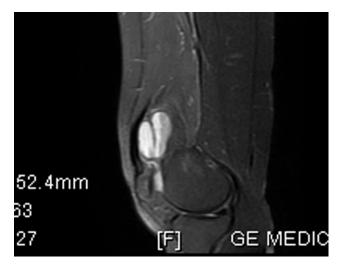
Sagittal magnetic resonance imaging sequence of right thigh shows ganglion cyst within suprapatellar pouch.
